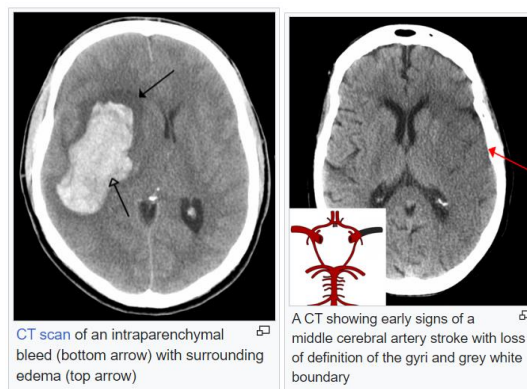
CT Scan Images of Hemorrhagic (left) and Ischemic (right) Stroke Patients<sup>4</sup>
